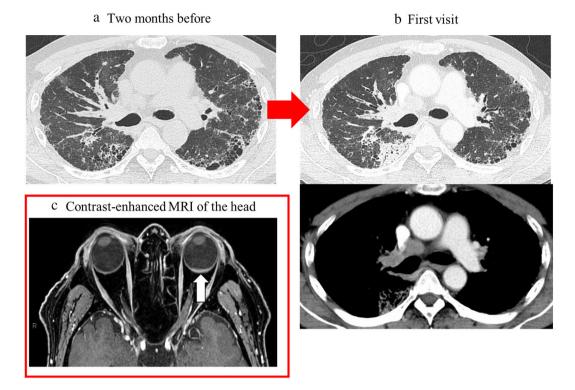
(a) Computed tomography (CT) scan image acquired 2 months prior to the first visit to our department and (b) at the time of the first visit to our department (b). (a) Reticular shadows and cystic clusters with a predominance of subpleural areas in bilateral lungs as ADM-associated interstitial lung disease are seen. (b) New mass shadow in the right upper lobe approximately 3.0 cm in length and diameter and mediastinal lymphadenopathies are newly observed. (c) Contrast-enhanced magnetic resonance imaging of the head, showing left retinal thickening (white arrow). Abbreviations: ADM: amyopathic dermatomyositis; CT: computed tomography; MR: magnetic resonance imaging
